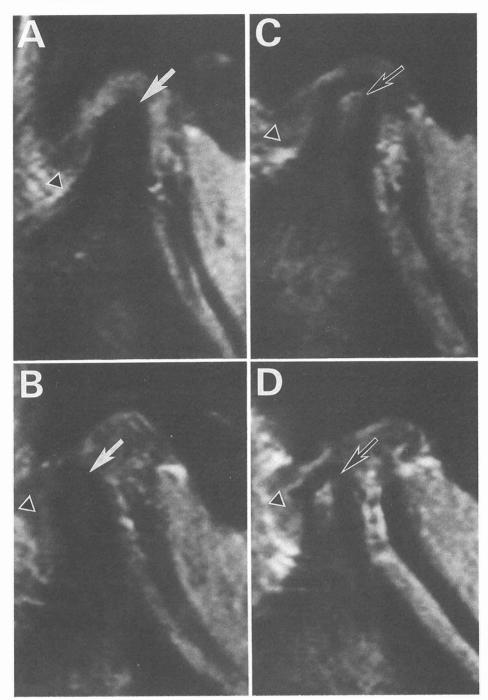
Sagittal T1-weighted images (FE 30/13, $\theta = 30^{\circ}$). Bilateral anterior disc displacement was seen in opening and closing mouth (black triangle), and flattening of the condyle (white arrow and black arrow) was also seen. A, Right TMJ on mouth closing. B, Right TMJ on mouth opening. A and B, Low signal intensity was observed in the area between the condylar head (white arrow) and mandibular notch. C, Left TMJ on mouth closing. D, Left TMJ on mouth opening. Cand D, The left mandibular condyle showed an area of high signal intensity surrounded by alow signal intensity area (black arrow).
